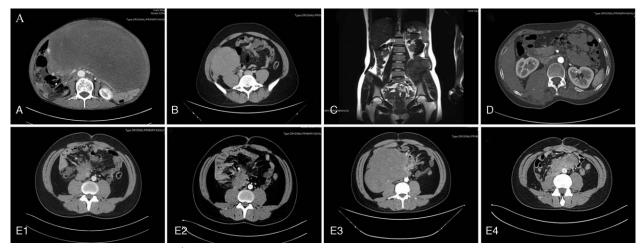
(A) Giant cystic and solid mass (40^{*}30 cm) originating from the retroperitoneal space. Liquefaction necrosis occurred, and compression of adjacent organs can be seen. (B) Soft tissue mass located in the right lower abdomen and pelvic retroperitoneal region, and infiltrate the right psoas, iliac muscles, and ureter. (C) MRI showing that the tumor located in the left retroperitoneum with a size of 7.6^{*}9.0 cm. (D) The tumor compressing the right kidney. (E1) Tumor with 7.0^{*}3.0 cm at the initial diagnosis (September 2011). (E2) No progression was observed (October 2012). (E3) Rapid growth of tumors was observed after 27 months (December 2013). And then surgical resection was performed. (E4) Stable disease was noted until now. MRI = magnetic resonance imaging.
